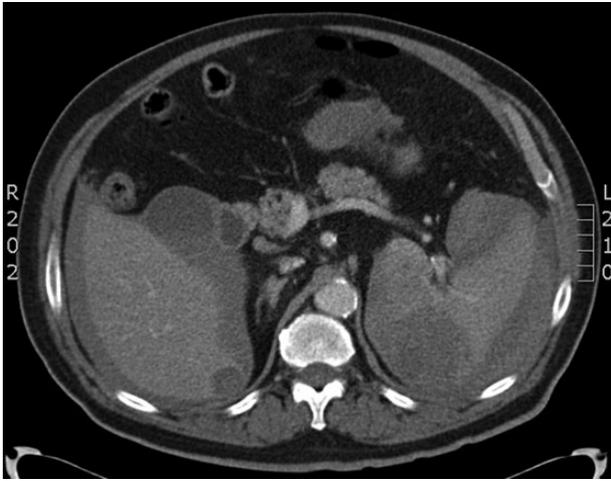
CT scan showing the abnormal spleen and the haemoperitoneum.
